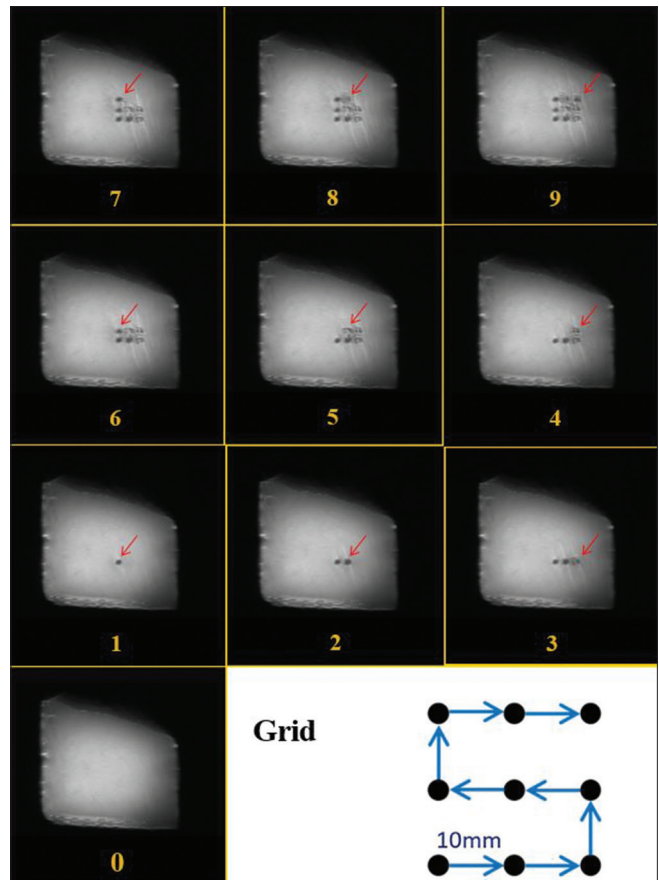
2D coronal T2-weighted fast spin echo images (repetition time = 2500 ms, echo time = 48 ms, flip angle = 180°, echo train length = 60, PB = 50 Hz/pixel, matrix size = 256 × 256, and field of view = 200 mm × 200 mm × 10 mm) acquired during sonication in a 3 × 3 grid (acoustic power of 60 W for 40 s) with a spatial step of 10 mm (time delay of 60 s) in the 3 T magnetic resonance imaging scanner. The sonication pattern is presented in the right bottom corner
